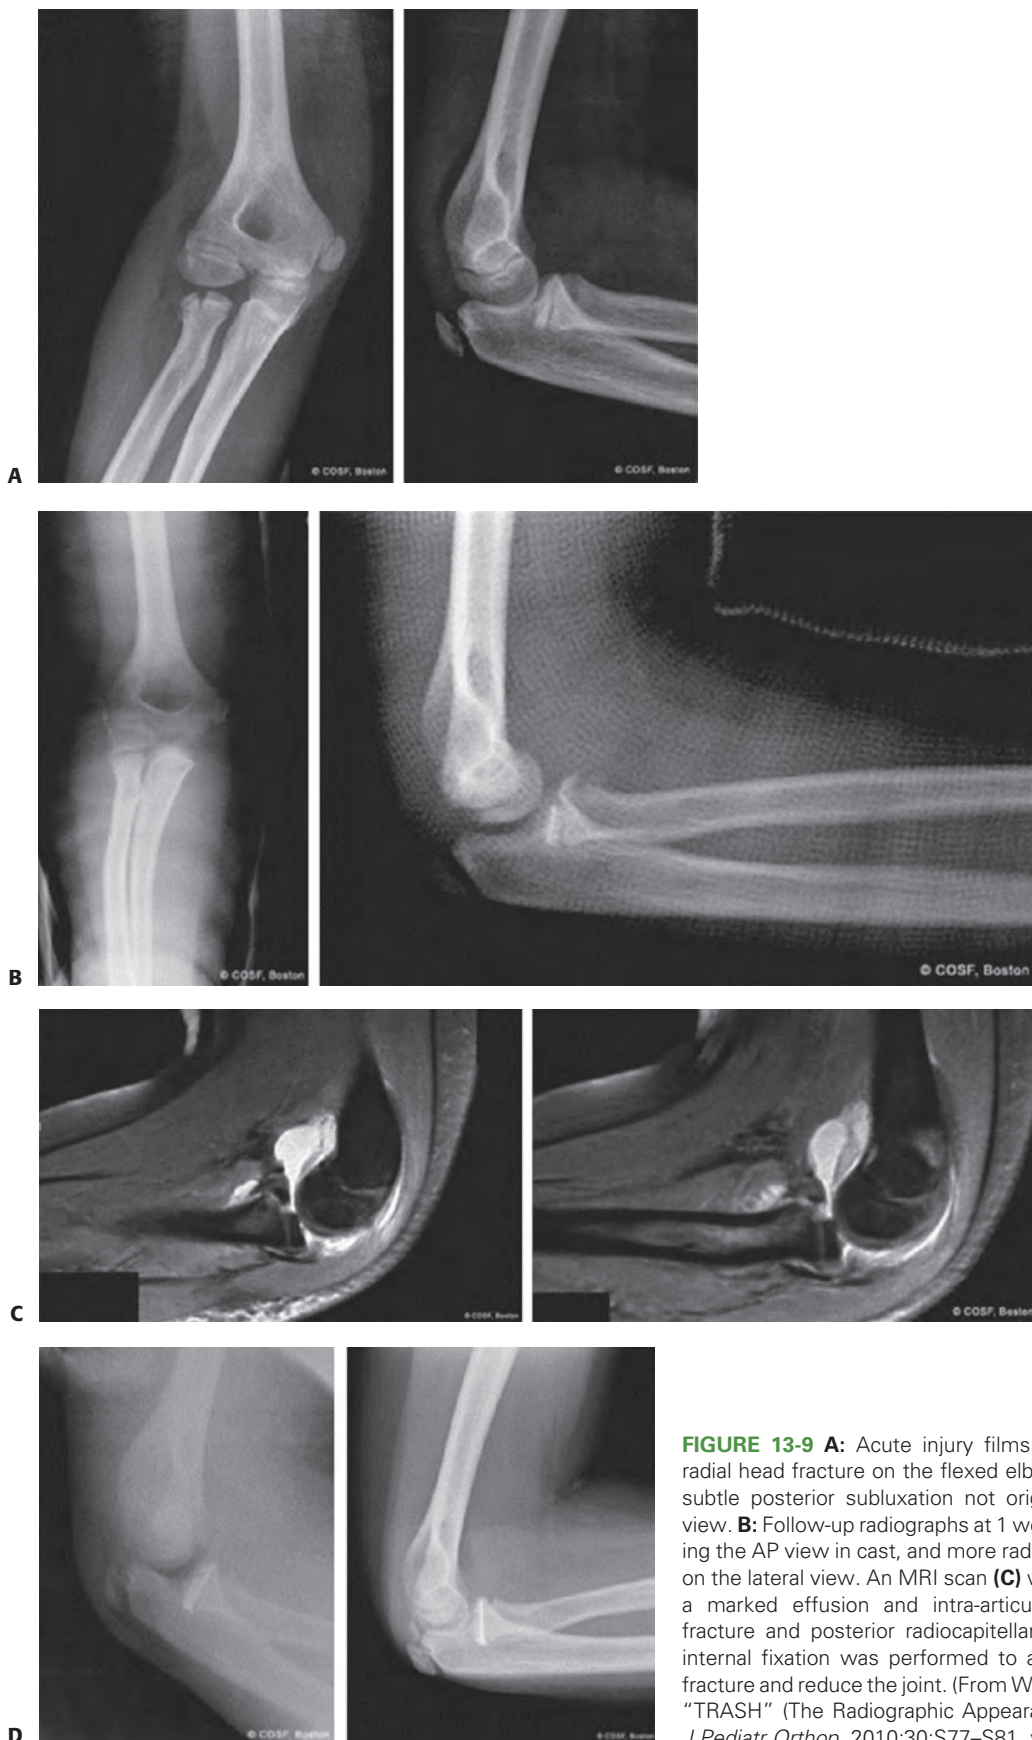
A: Acute injury films revealing small displacement of radial head fracture on the flexed elbow anteroposterior (AP) view and subtle posterior subluxation not originally appreciated on the lateral view. B: Follow-up radiographs at 1 week noted more difficulty interpreting the AP view in cast, and more radiocapitellar posterior displacement on the lateral view. An MRI scan (C) was ordered urgently and revealed a marked effusion and intra-articular displacement of radial head fracture and posterior radiocapitellar subluxation. D: Open reduction internal fixation was performed to anatomically align the radial head fracture and reduce the joint. (From Waters PM, Beaty J, Kasser J. Elbow “TRASH” (The Radiographic Appearance Seemed Harmless) Lesions. *J Pediatr Orthop.* 2010;30:S77–S81, with permission.)
